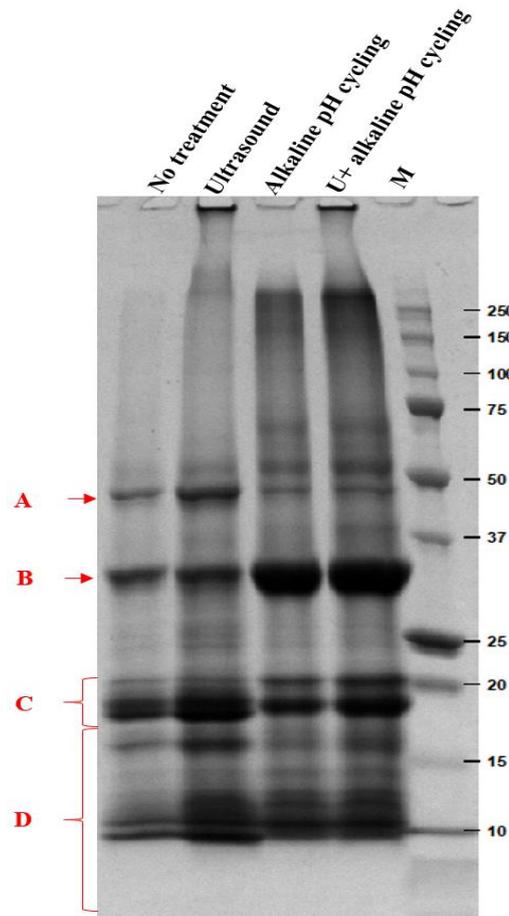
SDS-PAGE of soluble hemp proteins under different treatments. *M*, molecular mass marker in kDa. Labels above the lands indicate the used treatments. No treatment marked as a standard sample at 65 °C and pH 9. U + alkaline pH cycling, ultrasound co-treatment with alkaline pH cycling. Bands A-D indicate likely globulin albumin fractions of hemp proteins, see text for more details. The protein concentration for all samples in the SDS-PAGE loading buffer was adjusted to 1 mg/mL before loading.
